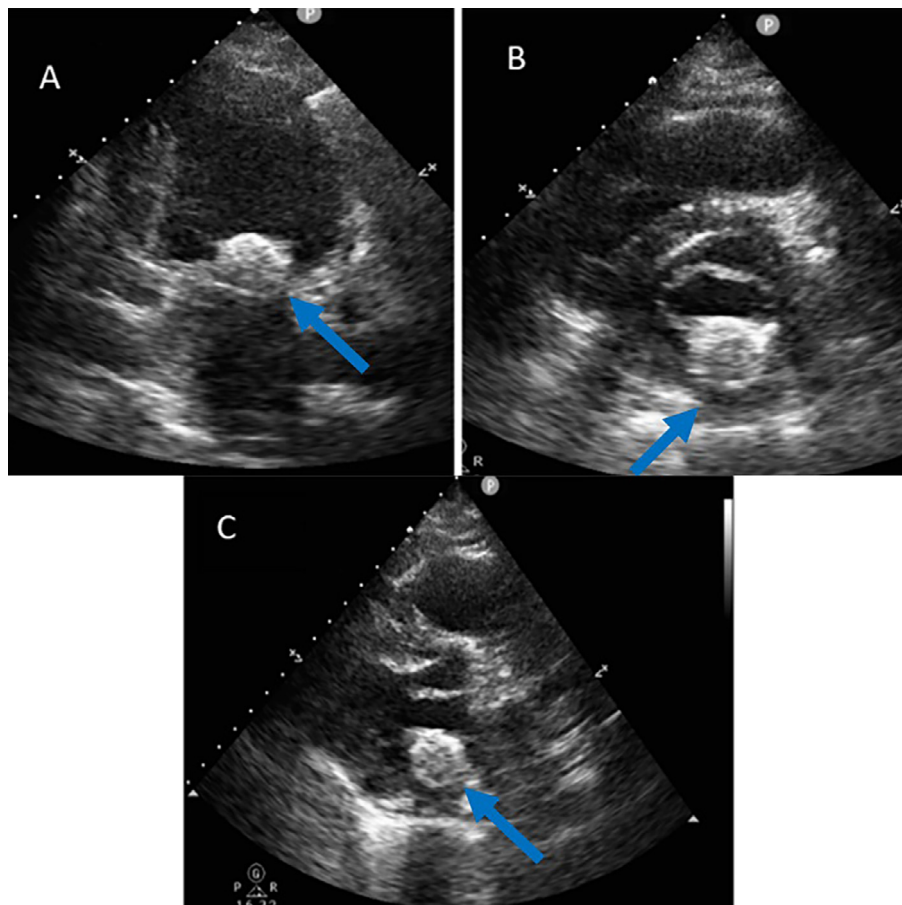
Transthoracic echocardiogram. Depicting echo dense spherical, tumor-like mass in the periannular posterior region close to the ventricular side of the posterior mitral leaflet (blue arrows). (A) A 2-chamber view; (B) parasternal short axis view; (C) parasternal long axis view.
